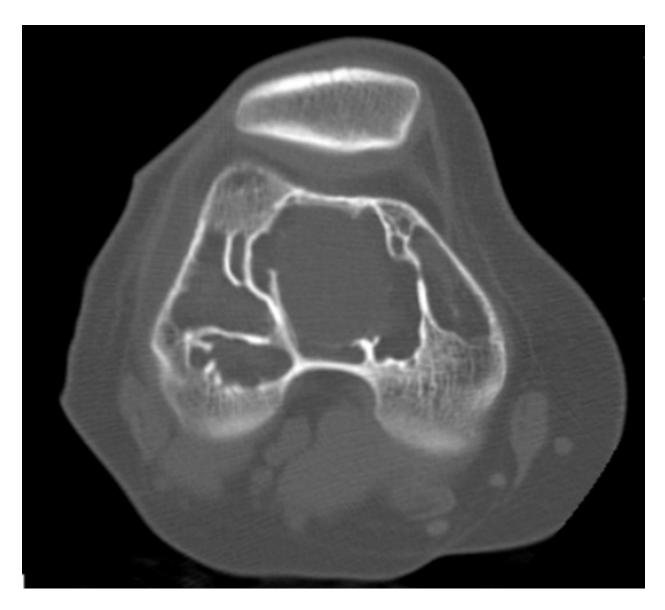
Solitary bone cyst. Axial computed tomography reformation of the right femoral bone reveals a multiloculated appearance well-defined lytic lesion. References: Serviço de Imagem Médica, Centro Hospitalar e Universitário de Coimbra, Faculdade de Medicina de Coimbra Medical Imaging Department and Faculty of Medicine, University Hospital of Coimbra, Portugal CT & MRI
